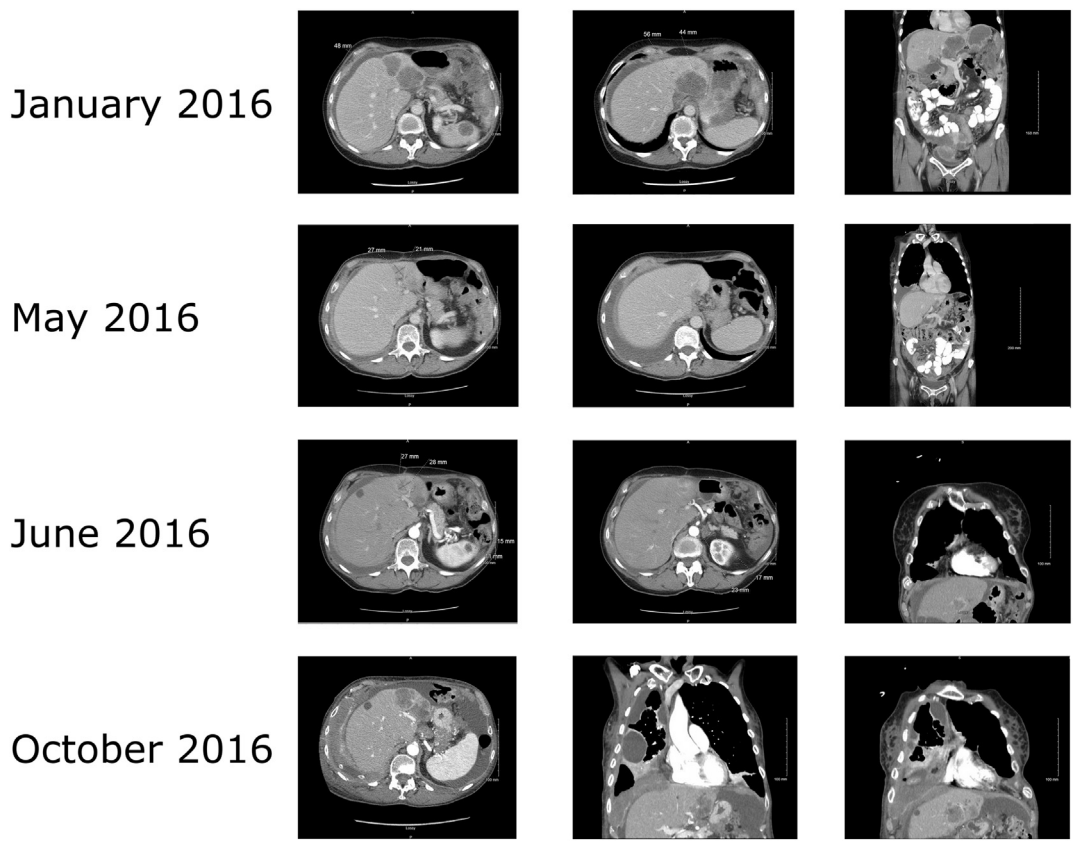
CT scans showing disease progression between January 2016 and October 2016. 1 A–C, January 2016. A. Significant interval progression of diffuse metastatic disease in the abdomen and pelvis including hepatic metastases (as indicated by the white arrows), splenic metastasis, diffuse omental and peritoneal carcinomatosis (including extensive serosal involvement of the stomach and bowel), diffuse pelvic tumor compressing the rectum and urinary bladder, metastatic lymphadenopathy, and several abdominal wall metastases. 2 D–F, May 2016. Extensive peritoneal carcinomatosis throughout the abdomen and pelvis and liver metastases which appears markedly improved since 1/6/2016 (as indicated by the white arrows). 3 G–I, June 2016 G. No pulmonary embolus. H. Hepatic metastases. There is interval growth and prominent enhancement of the left hepatic mass (as indicated by the white arrow). Other included hepatic metastases are not significantly hyperenhancing and remain similar in size and relatively low in density. 4 J–L, October 2016, Interval increase of extensive peritoneal and omental carcinomatosis in the visualized portions of the abdomen and pelvis with interval increase of large pelvic masses. Interval increase of hepatic masses/metastasis (as indicated by the white arrows). Interval increase of ascites in the visualized abdomen and pelvis.
